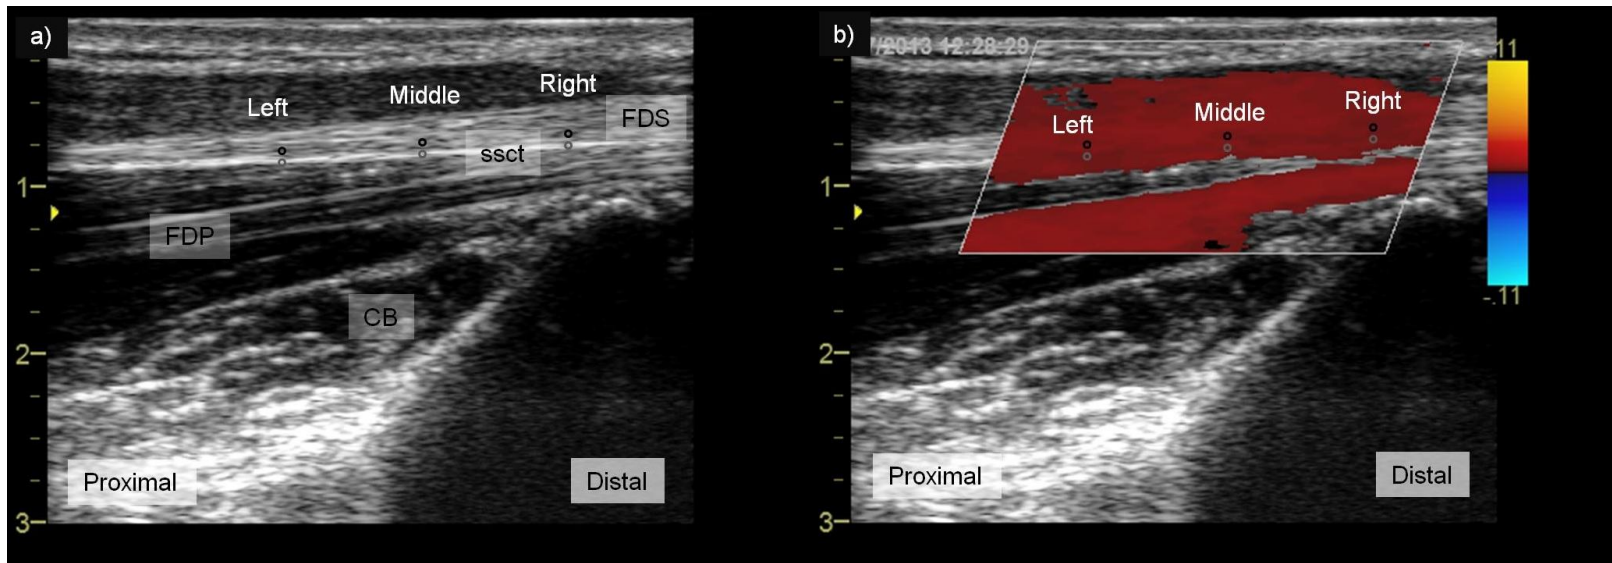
Tendon-SSCT motion. A colour Doppler assessment measured relative motion between the tendon and SSCT for each participant. The (a) grayscale echograms identified the long finger tendon as a band of hypoechoic, fibrillar, striations that was bordered by a thin, hyperechoic SSCT layer (FDS, flexor digitorum superficialis tendon; SSCT, subsynovial connective tissue; FDP, flexor digitorum profundus tendon; CB, carpal bone). The grayscale echograms guided the placement of 6 markers over the tissue of interest and overlaying (b) colour maps. Pairs of markers were positioned at a left, middle, and right region of interest within the color maps, with each pair representing the tendon (black marker) and adjacent SSCT (gray marker) tissue velocities. The tissue velocities were integrated to obtain displacement profiles. Three cycles of flexion (positive deflection) and extension (negative deflection) are shown for (c) a control and (d) CTS symptomatic. The dashed arrows indicate the total tendon displacement (D_{FDS}) and associated SSCT displacement (D_{SSCT}) that was measured for a typical flexion excursion.
